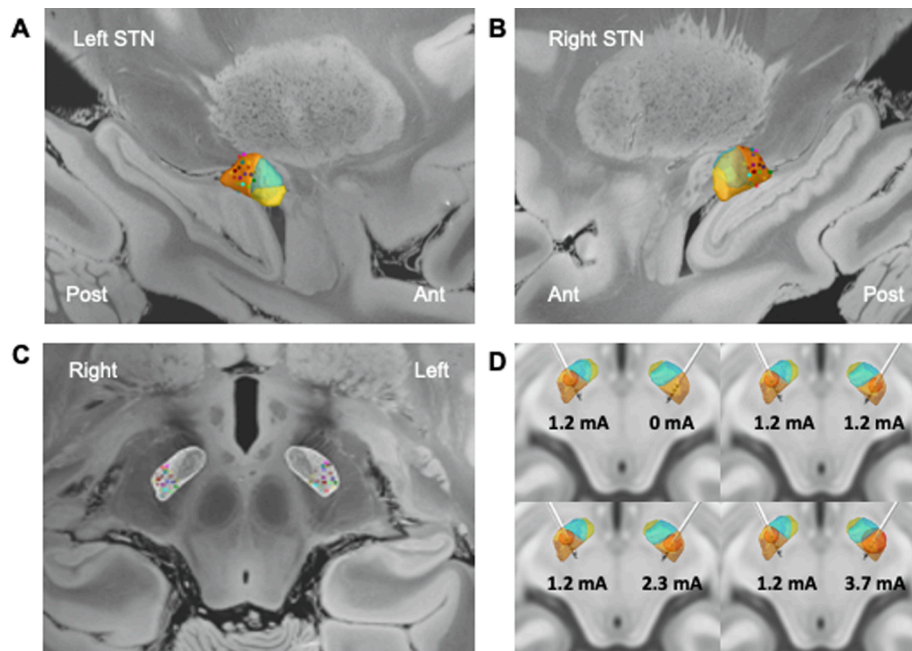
Active contact locations and the volume of tissue activated in a representative patient. Active contacts were in the sensorimotor part of the subthalamic nucleus in all patients (A–C). Background template: a 7 T MRI ex vivo 100- μ m human brain. D. The volume of tissue activated in a representative patient, using 3 T anatomical T1 image. Orange: sensorimotor, blue: associative, yellow: limbic part of the STN.
